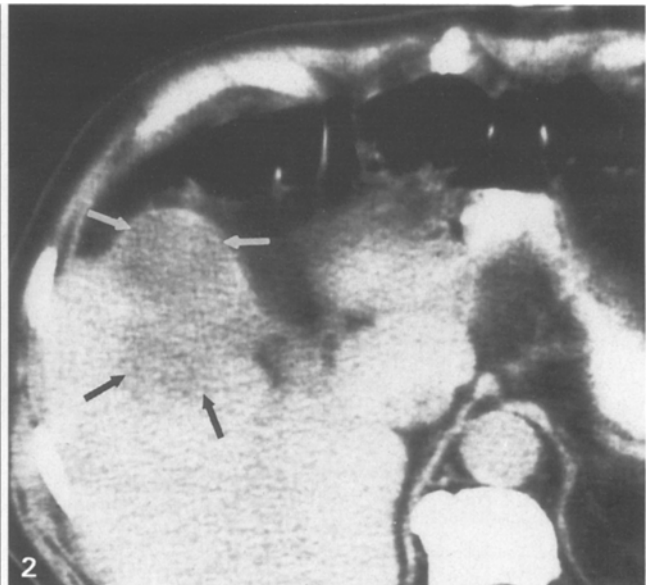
CT scan shows an intrahepatic fluid collection (*black arrows*) adjacent to the gallbladder (*white arrows*) in an 81-year-old man who was septic and comatose. During percutaneous cholecystostomy pus was obtained from the gallbladder, but his fever and leukocytosis persisted. At surgery he was found to have a gangrenous gallbladder, and he died postoperatively.
